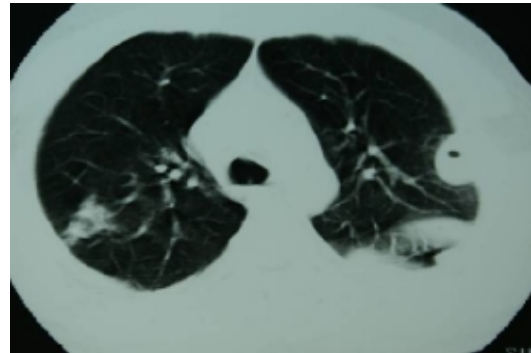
Chest CT scan. Nodules located subpleurally measuring approximately 2-3 cm in diameter with central necrosis on both sides. Necrotic center in nodules is compatible with septic embolism.
